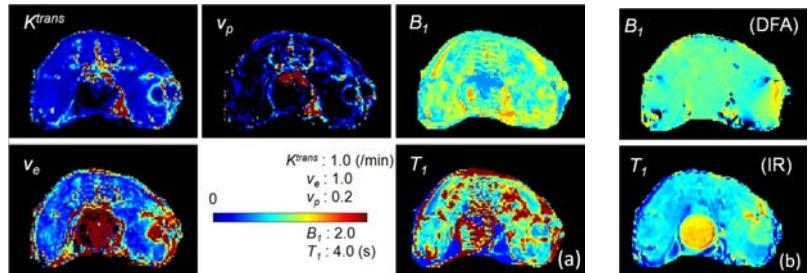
(a) DCE-MRI estimated parameter color maps. (b) DFA B_1 and IR T_1 color maps.
